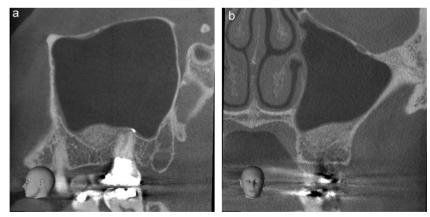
Cone-beam computed tomography images at postoperative month 6. 3a Sagittal view. 3b Coronal view.
